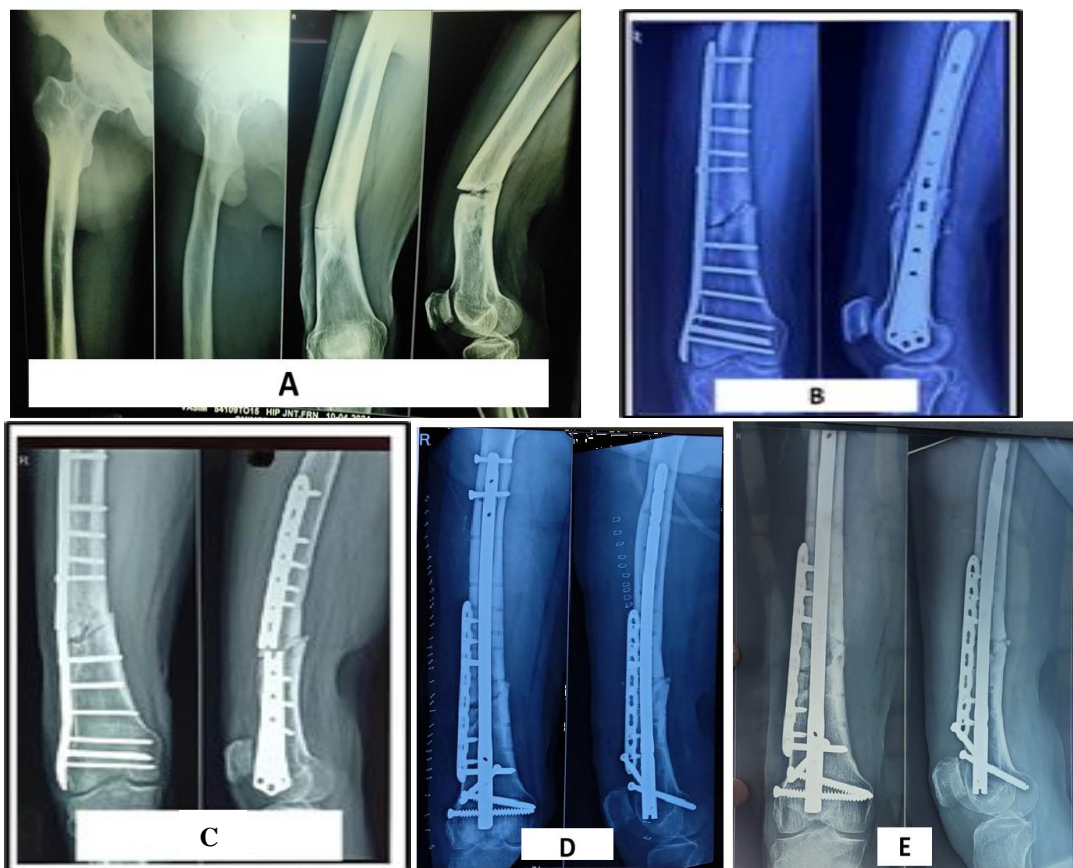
(A): Preoperative radiographs of a 56-year-old male showing lower third shaft femur fracture; (B): immediate Postoperative radiographs showing management of fracture via distal femur locking plate; (C): presentation of the patient 4 months post op with implant failure and non-union of fracture; (D): post op X-ray after revision surgery managed with orthogonal dual implantation; (E): Follow up X-ray after 6 months of revision surgery showing union.
